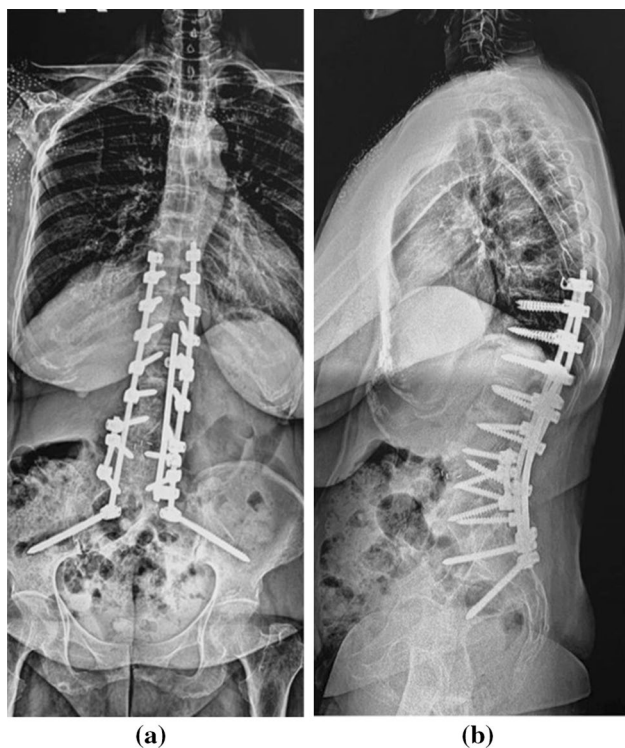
Full spine X-rays 2 years after the surgery showing a satisfying alignment with a stable construct
